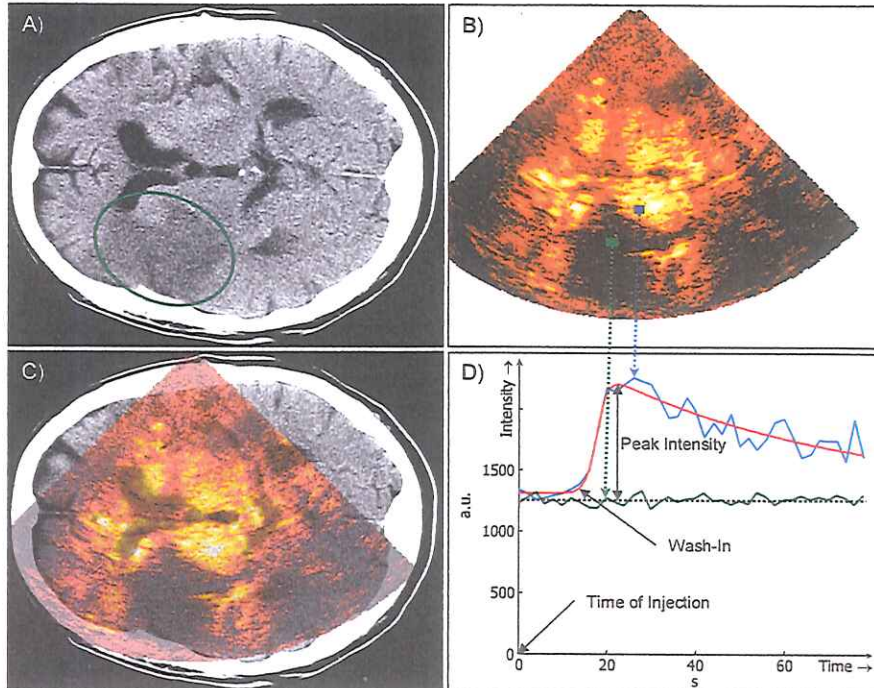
Brain perfusion images and TICs. A): Follop-up CT scan of a stroke patient showing the infarcted tissue (green ellipse). B): Ultrasound perfusion image (peak intensity) showing the perfusion deficit in the acute phase. C): The overlay of A) and B) confirms the localization of the infarction. D) Time-intensity curves derived from perfused and unperfused ROIs.
